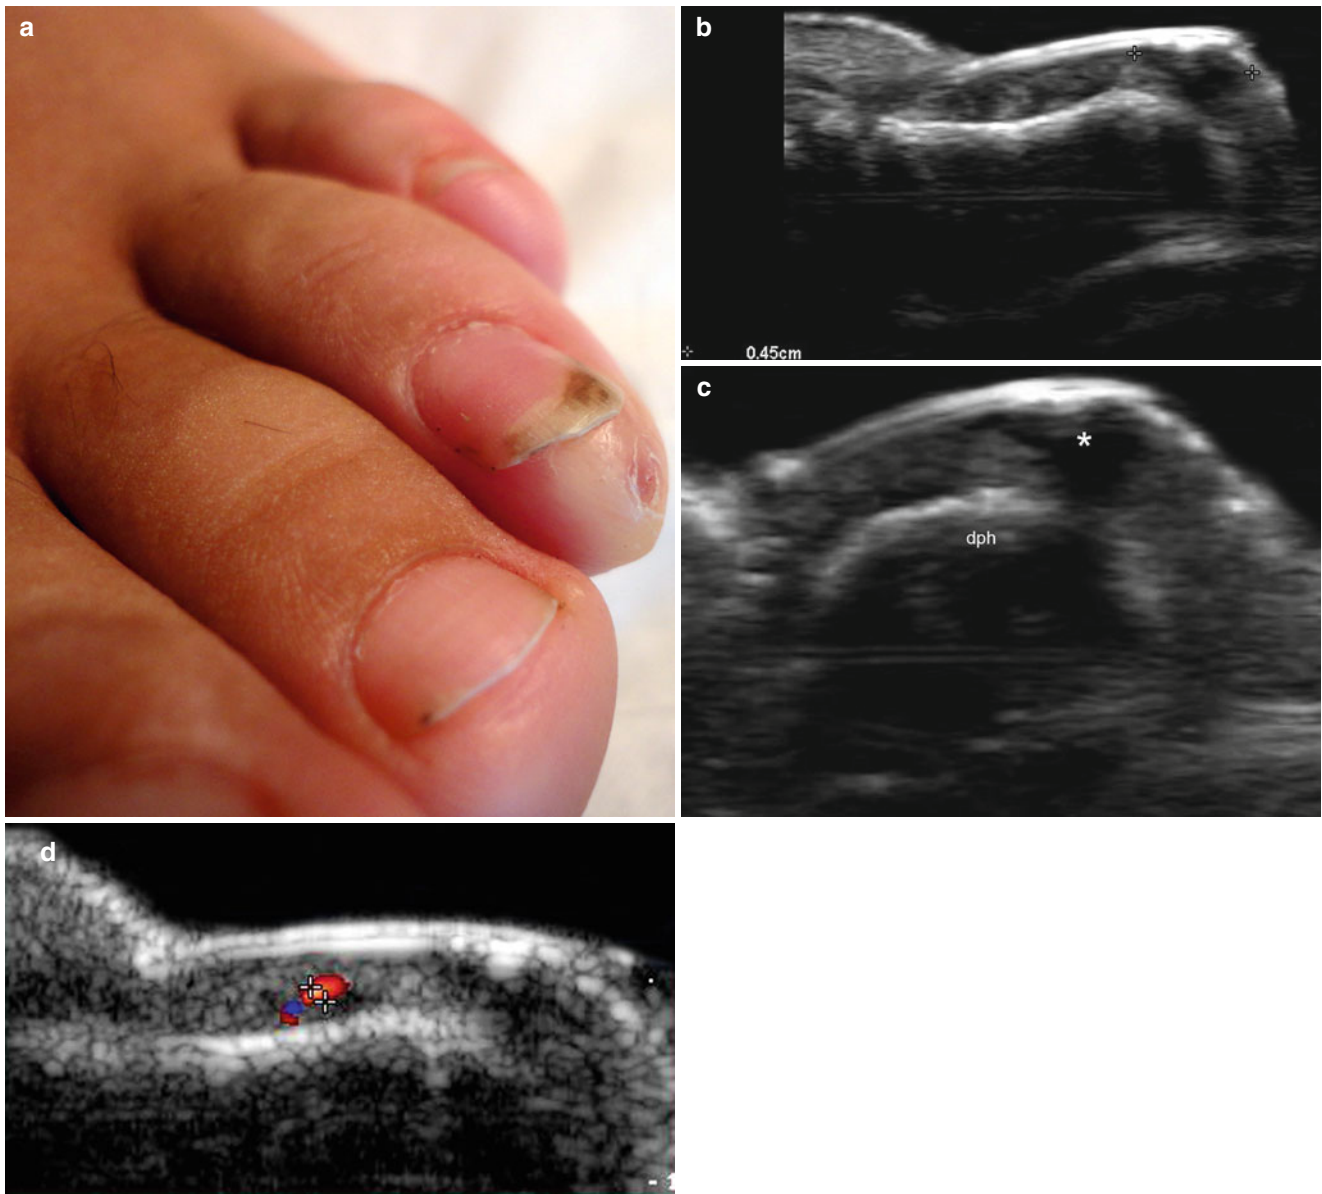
(a–d) Wart. (a) Clinical image shows pigmentation and dystrophic changes in the nail plate of the left fourth toe. Hyperkeratosis and small erosion in the skin are also detected in the hyponychium. (b, c) Grey scale ultrasound images of the left fourth toe (b longitudinal view; c transverse view) show a 4.5 mm long well-defined fusiform-shaped
